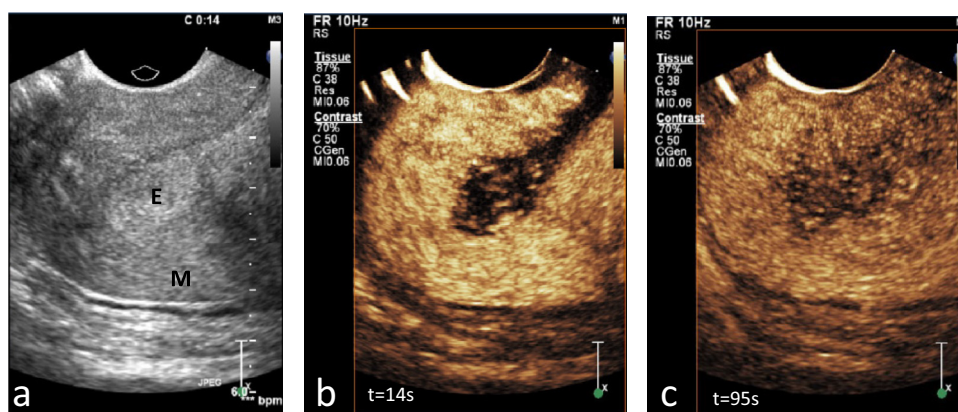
Gray-scale ultrasound and contrast-enhanced ultrasound scans of a normal uterus: (a) Gray-scale ultrasound image. (b) Contrast-enhanced ultrasound image obtained 14 s after contrast injection ($t = 14$ s), revealing initial enhancement of the myometrium. (c) Contrast-enhanced ultrasound image obtained 95 s after contrast injection ($t = 95$ s), revealing hypo-enhancement of the endometrium compared with surrounding myometrium. E = endometrium, M = myometrium.
